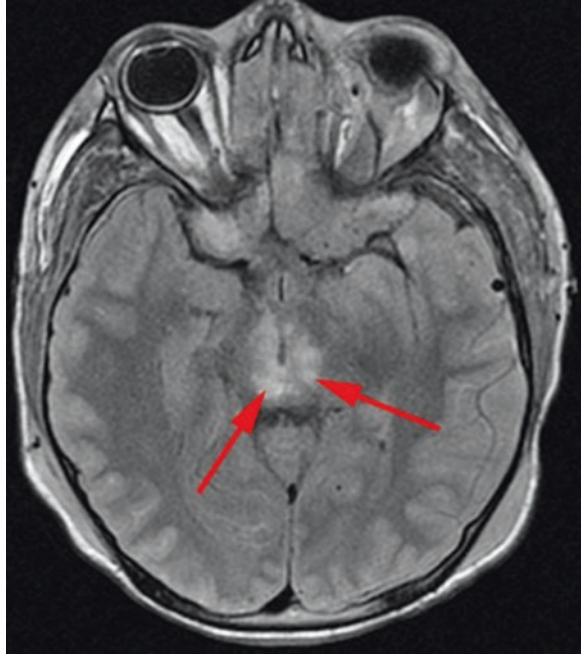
Axial T2 FLAIR (midbrain mesencephalic injury, red arrow)
